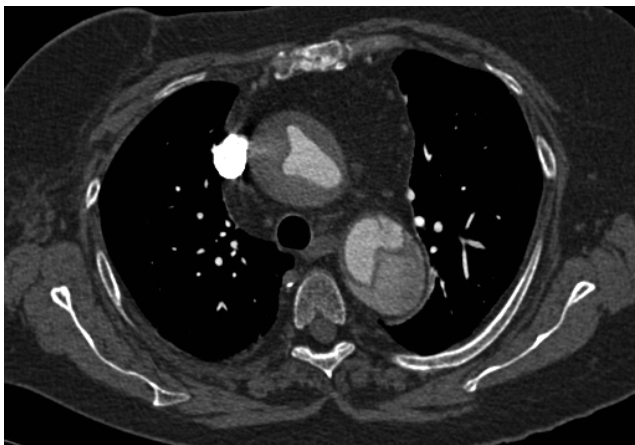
CT scan with contrast injection: type A aortic dissection
